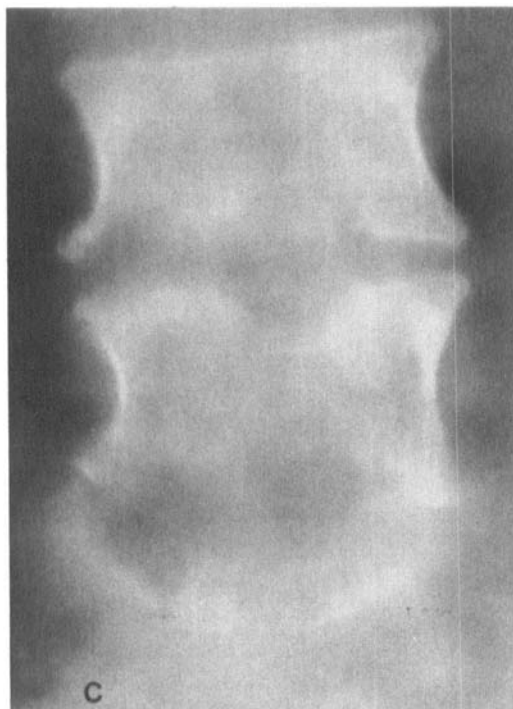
Plain radiography and multidirectional (spiral) tomogram of the lumbar spine of Case 3.
